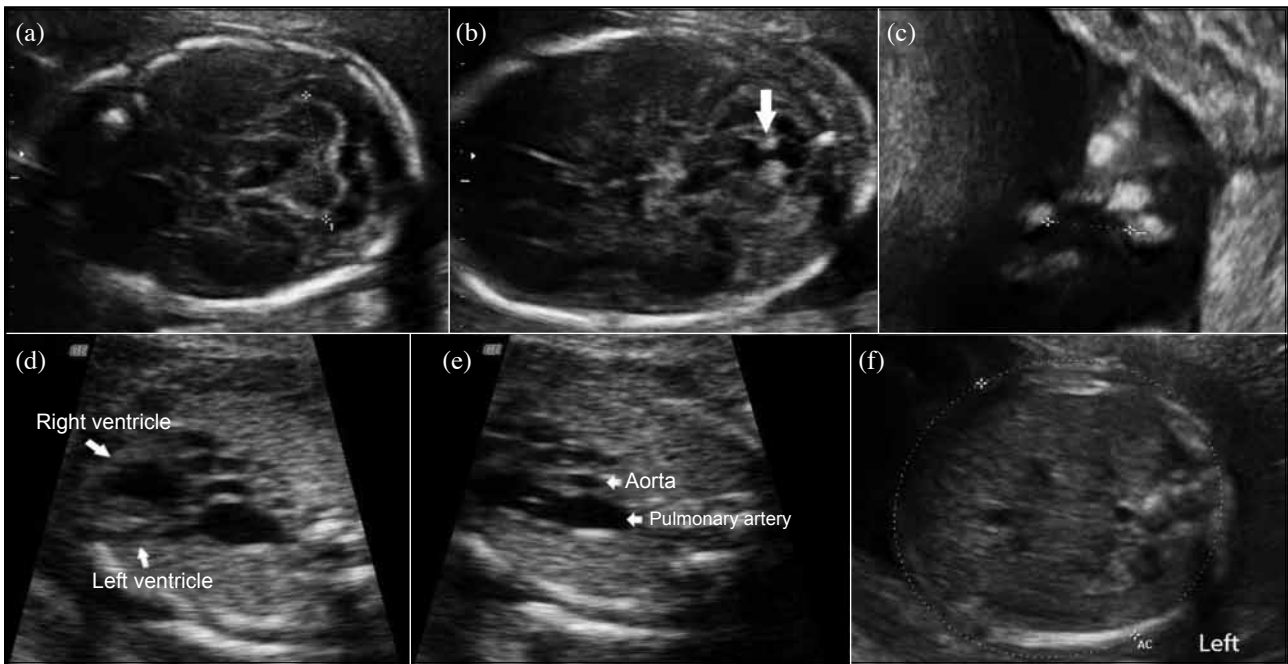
Prenatal ultrasound at 22 weeks' gestation showing (a) normal cerebellar hemispheres and posterior fossa (transcerebellar diameter=2.28 cm), (b) a defect in the inferior cerebellar vermis (arrow) that communicates with the 4th ventricle signifying Dandy walker variant anomaly, (c) median cleft lip (size=1.00 cm). (d) Four-chamber view and (e) three-vessel view showing hypoplastic left heart with narrow aorta and (f) absent stomach bubble on transverse view of the abdomen.
